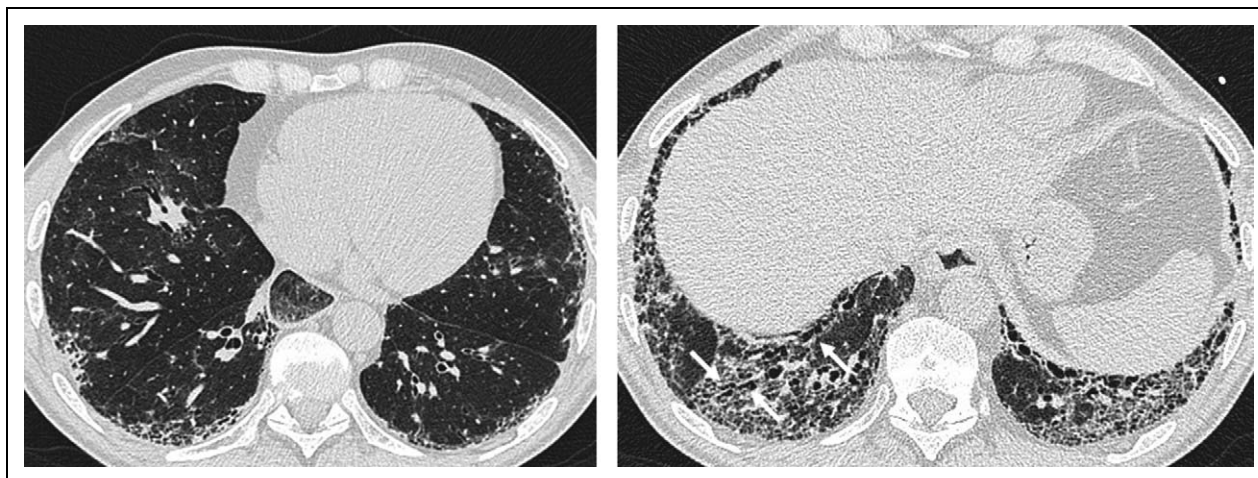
CT of a 65-year-old man with Scleroderma-associated interstitial lung disease, showing predominantly basal ground glass admixed with reticulation and obvious traction bronchiectasis (arrows), in keeping with an established fibrotic non-specific interstitial pneumonia (NSIP) pattern.
